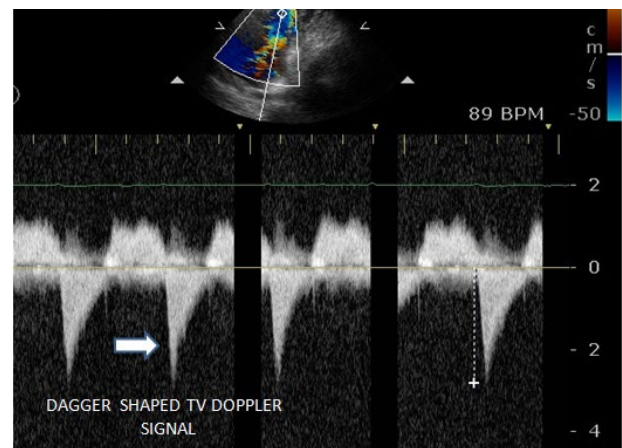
Continuous wave Doppler signal from TV shows dagger shaped profile with early peaked velocity.
